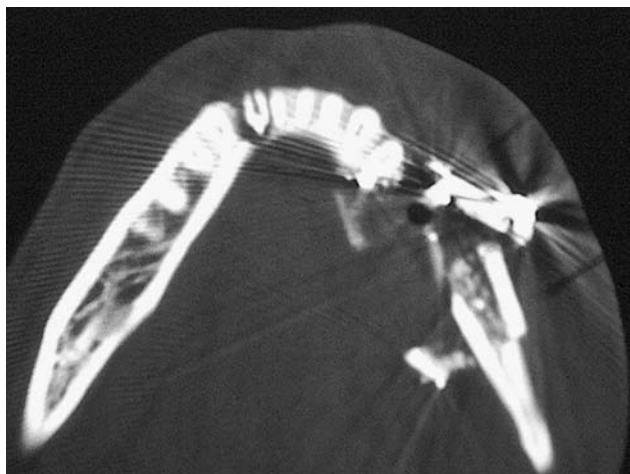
Computed tomography (CT) of the mandible, demonstrating comminution of the body.
